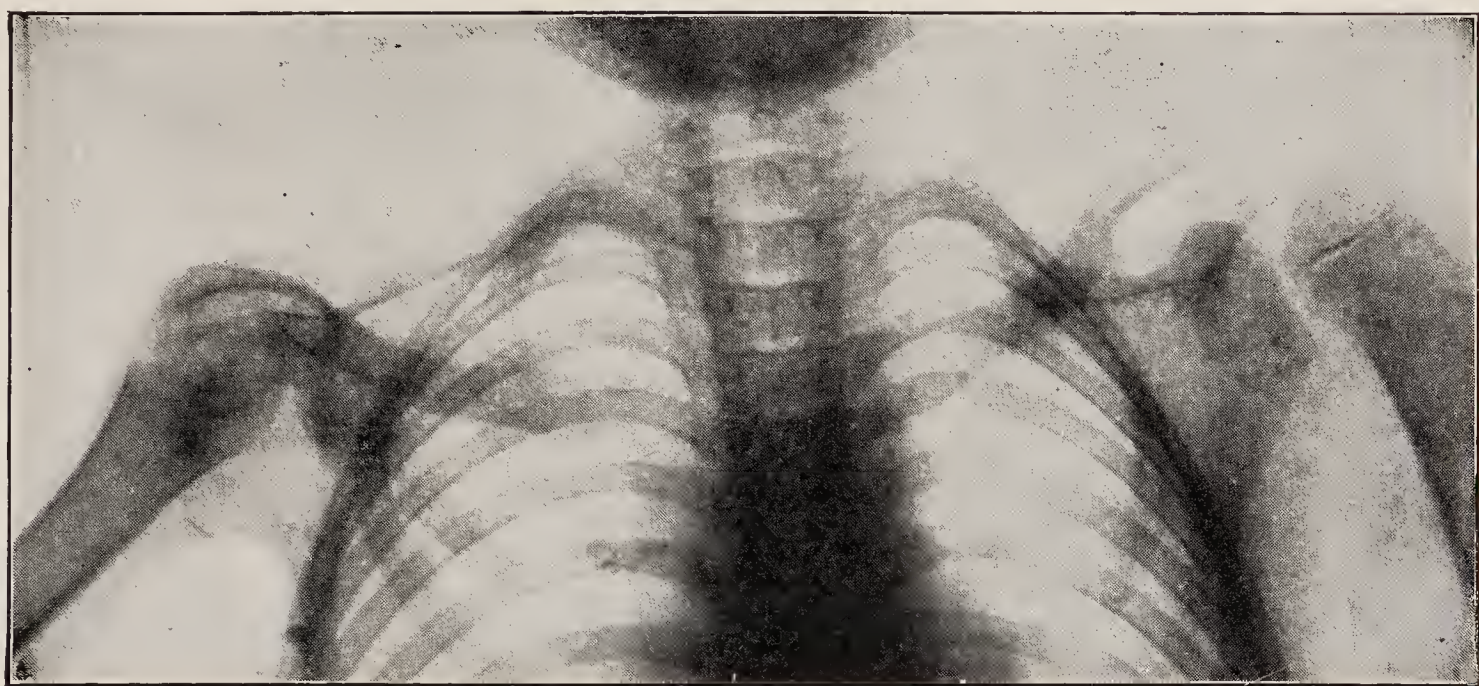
X-ray of right shoulder, showing lipping of the acromion. The dark, curved line on this side is due to the overlapping of the acromion and clavicle and defines the lower edge of the acromion, showing in contrast to the other side how the tip is curved down.
